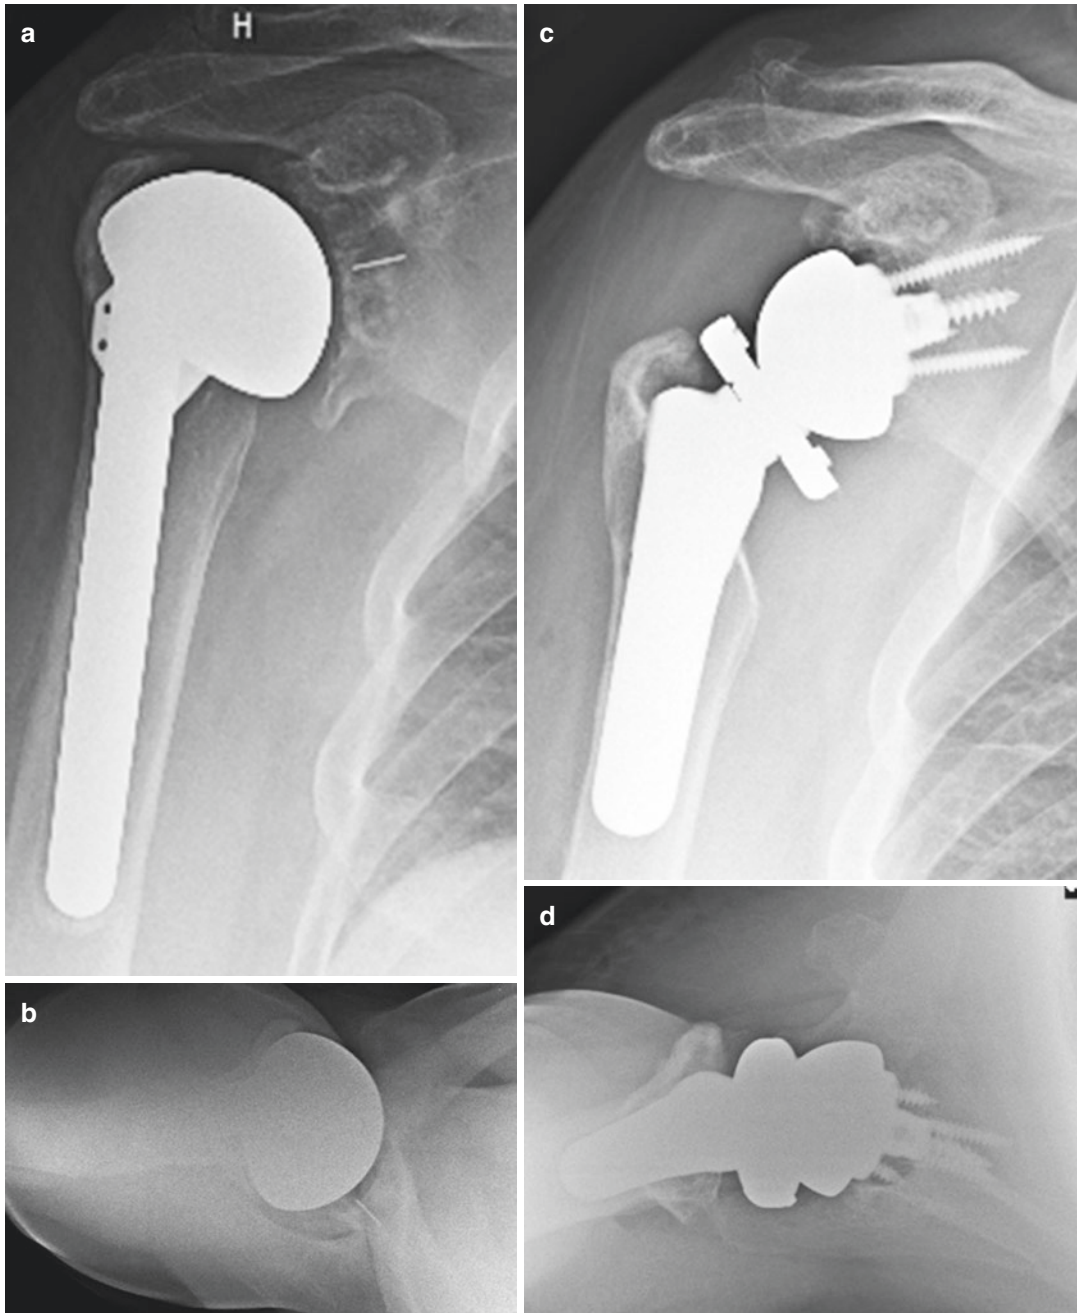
A failed aTSA due to glenoid wear and loosening of both the humeral and glenoid components as seen on AP (a) and lateral (b) radiographs. Due to glenoid bone
